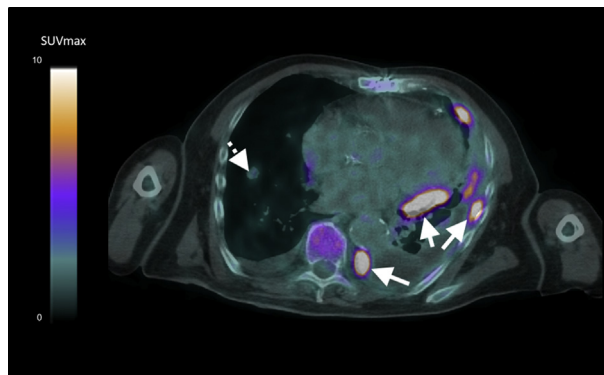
Axial slice of ^{18}F -FDG-PET imaging revealing distant hypermetabolisms in a lung nodule (white dotted arrow) and pleural thickenings (white solid arrows) related to metastasis. ^{18}F -FDG, ^{18}F -Fluorodeoxyglucose; PET, positron emission tomography.
